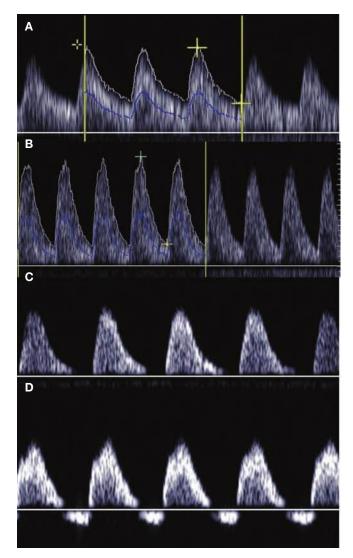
Doppler velocity waveforms. A. Normal waveform with normal S/D ratio. B. Increased impedance to flow with abnormally elevated S/D ratio. C. Absent end-diastolic flow. D. Reversed end-diastolic flow.
